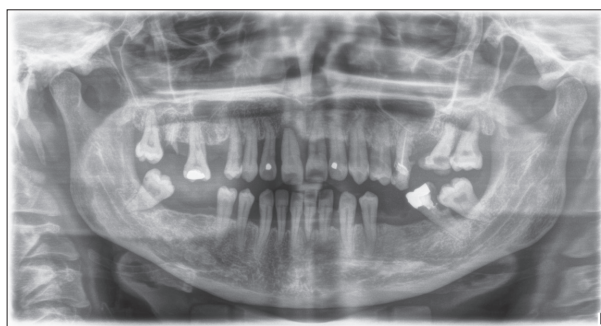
Orthopantomographic image of Patient 1
